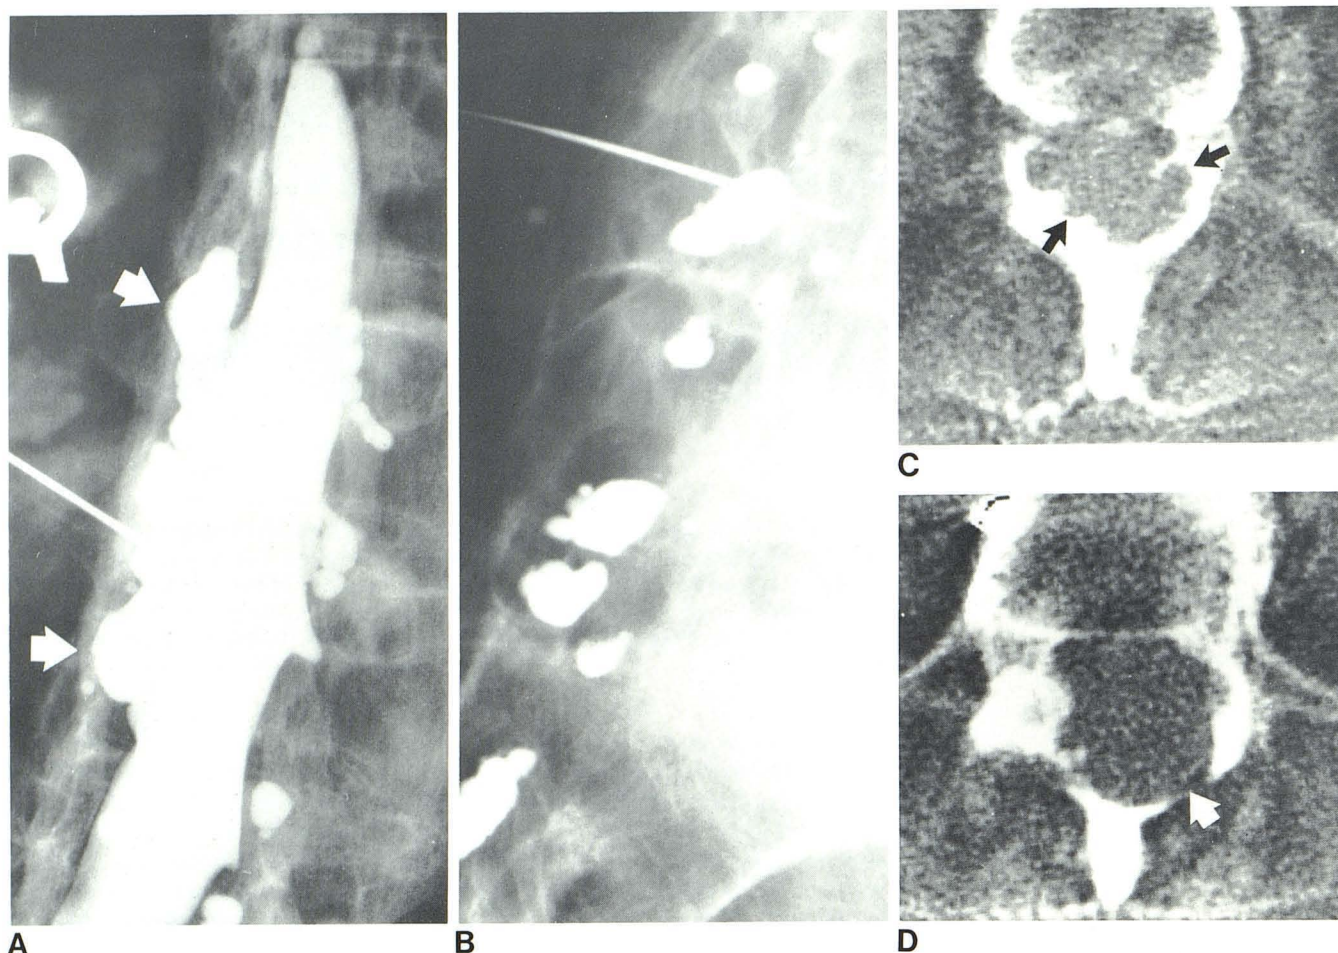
Case 1. A, Lumbar myelogram, oblique view. Multiple subarachnoid diverticula (arrows) communicate with thecal sac in L2–L5 region. B, Standing lateral view of lower lumbar spine. Residual contrast material in multiple, posteriorly situated diverticula. C and D, CT scans. Asymmetric erosions (arrows) of laminae and spinous processes of vertebrae at multiple levels correspond to diverticula seen on myelography.
